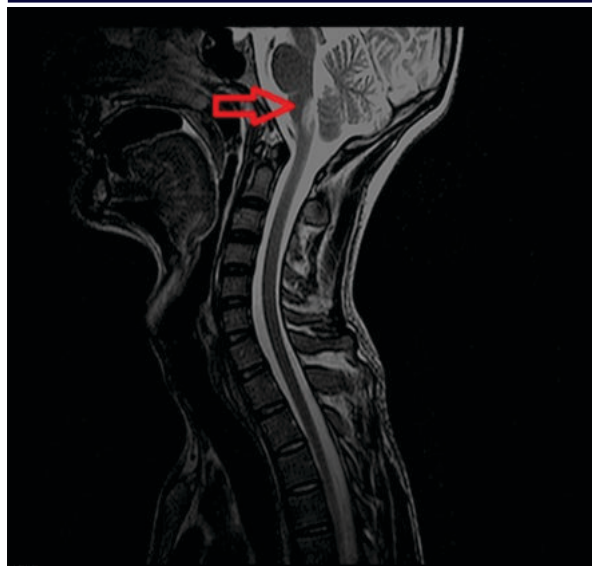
T2 MRI Saggital Section Demonstrating Dorsal Medullary/Area Postrema Hyperintensity
